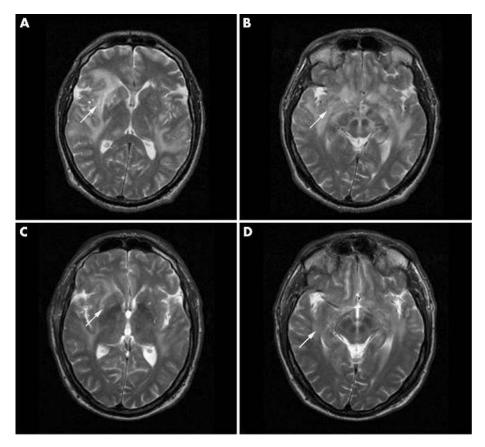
(A, B) Axial T₂ weighted fast spin echo MR images of the brain show increased signal intensity in the bilateral white matter and basal ganglia (arrows). (C, D) Follow up MRI shows a dramatic improvement of the white matter and basal ganglia abnormalities only 8 weeks after starting treatment
